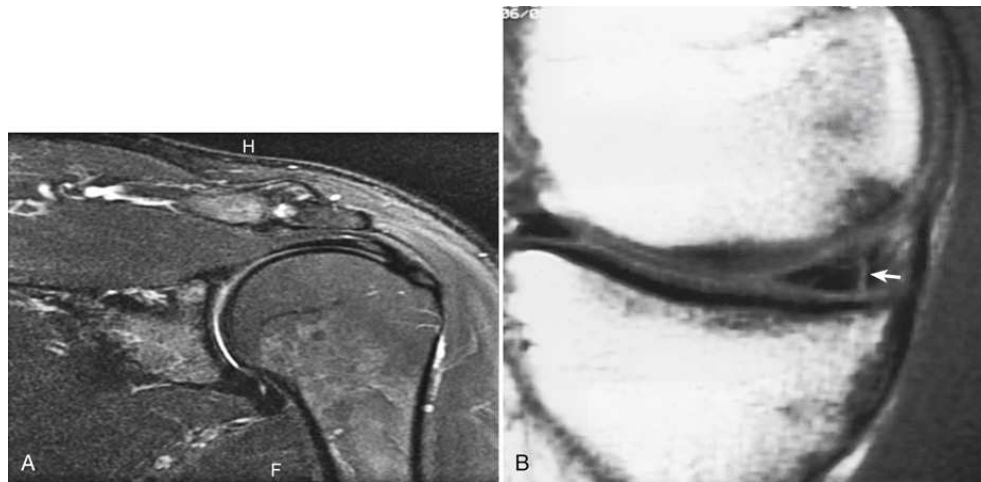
(A) Non-contrast-enhanced MRI of shoulder. (B) Non-contrast-enhanced MRI of knee, showing torn medial meniscus (arrow).
